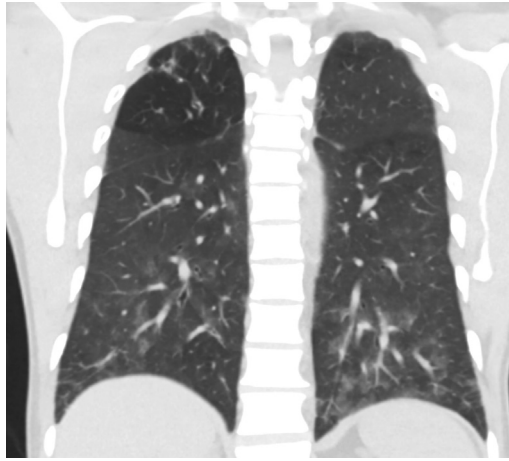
Cytomegalovirus in a 52-year-old man status postrenal transplant. Coronal chest CT with dominant findings of bilateral lower lobe peribronchovascular ground-glass opacities. There are a few nodules in the right lung apex. (Courtesy of Brent P. Little, MD, Jacksonville, Florida.).
